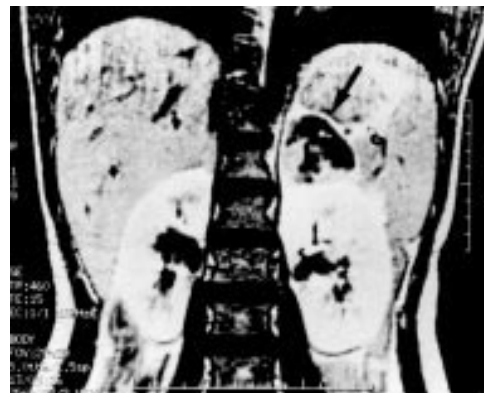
Magnetic resonance imaging scan showing a left adrenal mass (arrow).
